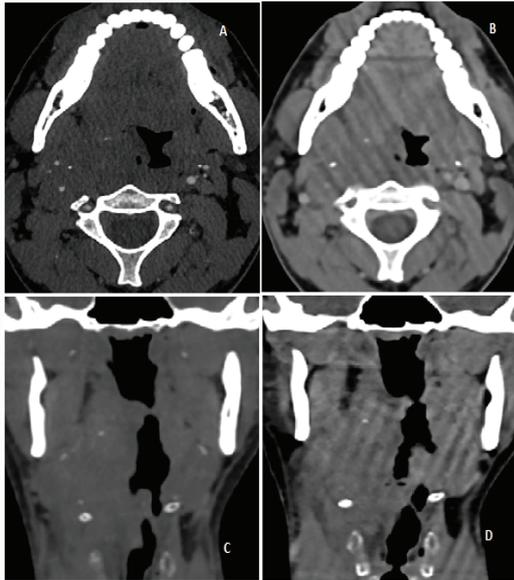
Axial (A,B) and coronal (C,D) CT-images of the neck. Right sided retropharyngeal swelling with a small hyperdensity (white arrow; spot-sign) in the arterial phase (A,C), increasing in the portalvenous phase (B,D).
